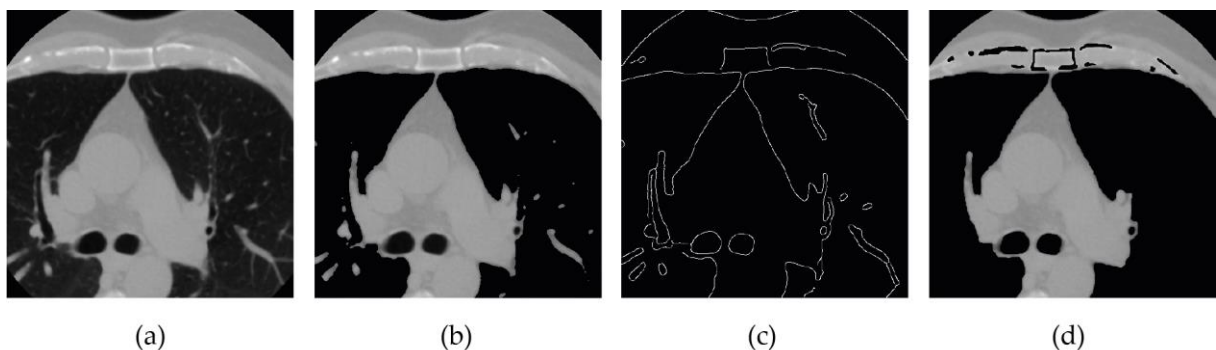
Image segmentation methods based on grey level features. Original CT image (a); Threshold-based method output (b); Edge-based method (Canny Edge Detector) output (c); Region-based method output (d).
